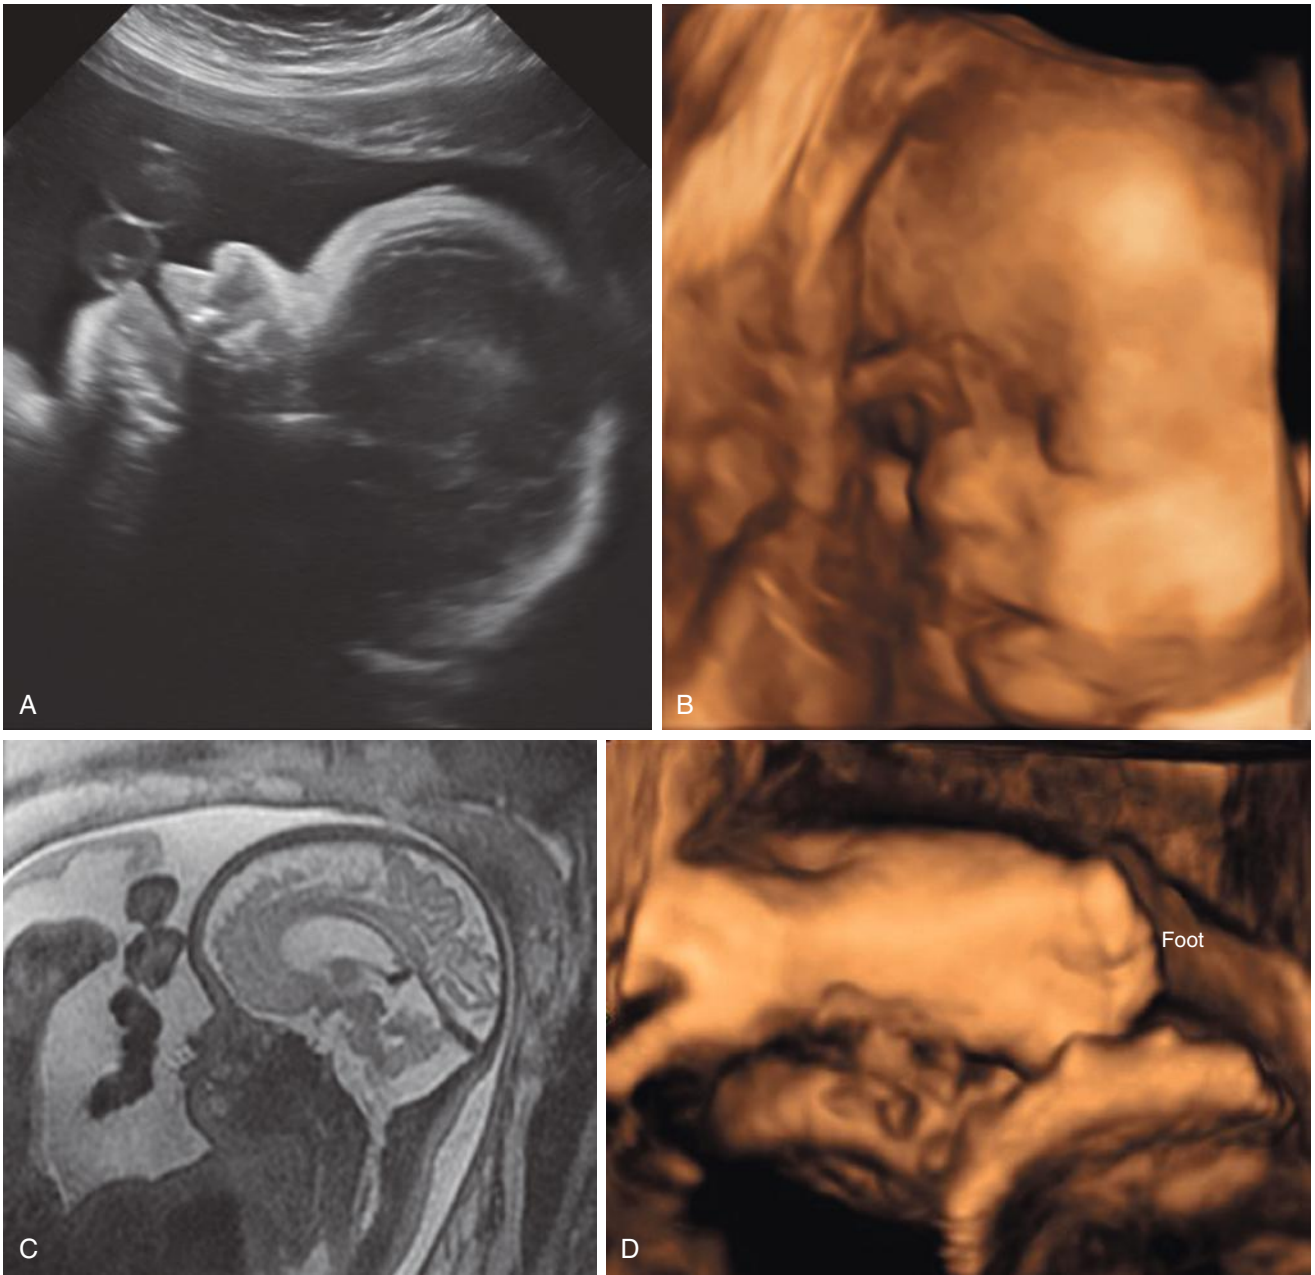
Apert syndrome. Ultrasound images demonstrating frontal bossing and midface hypoplasia on two-dimensional (2D) (A) and 3D (B) images, as well as by magnetic resonance imaging (C). Ultrasound image also demonstrated syndactyly of the foot (D), which is characteristic of Apert syndrome.
